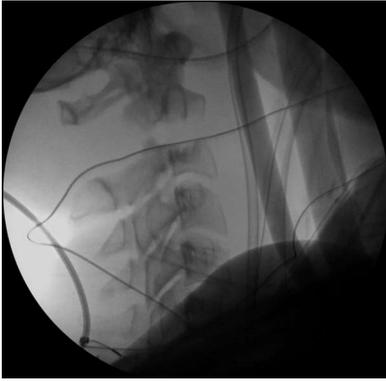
Lateral X-ray image showing persistent distraction in halo brace.
